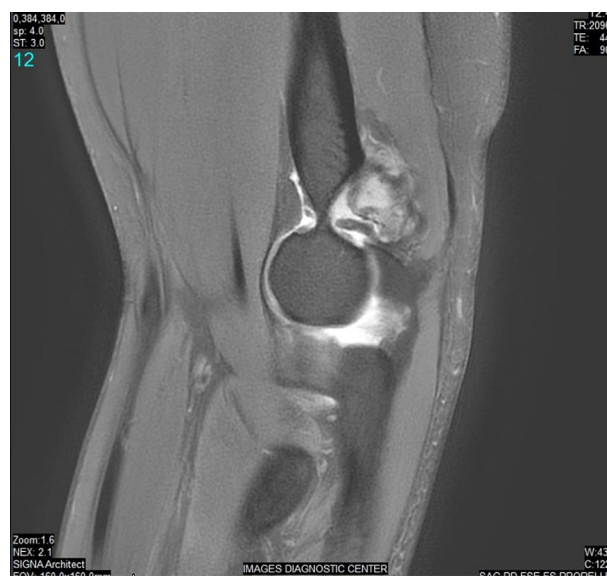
Axial magnetic resonance image (MRI) section of the right elbow showing an intra-articular osseous mass.
